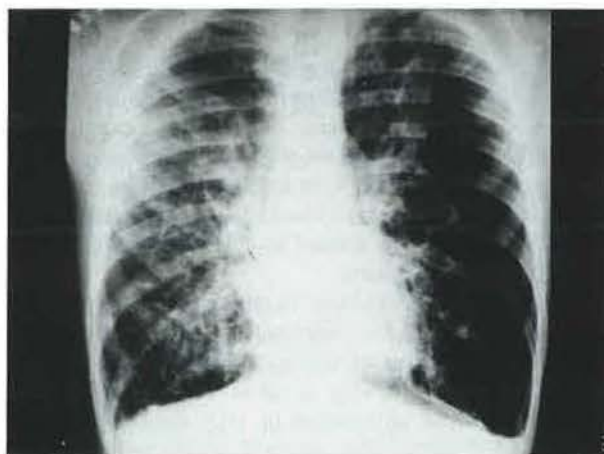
Chest X-ray showing subtotal left pneumothorax with bilateral multiple small cystic lesions.
